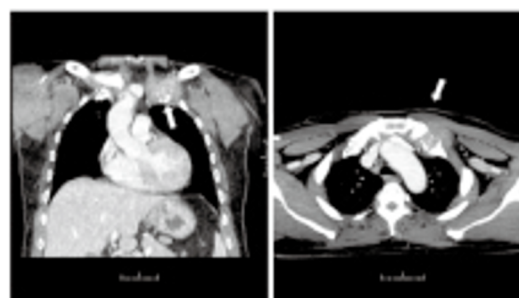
Case 1: CT imaging showing left clavicular lesion with swelling of soft tissues.
